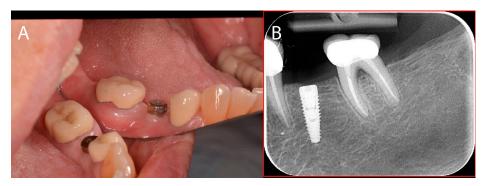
1-year follow up. (A) the final restoration; (B) periapical X-ray.
